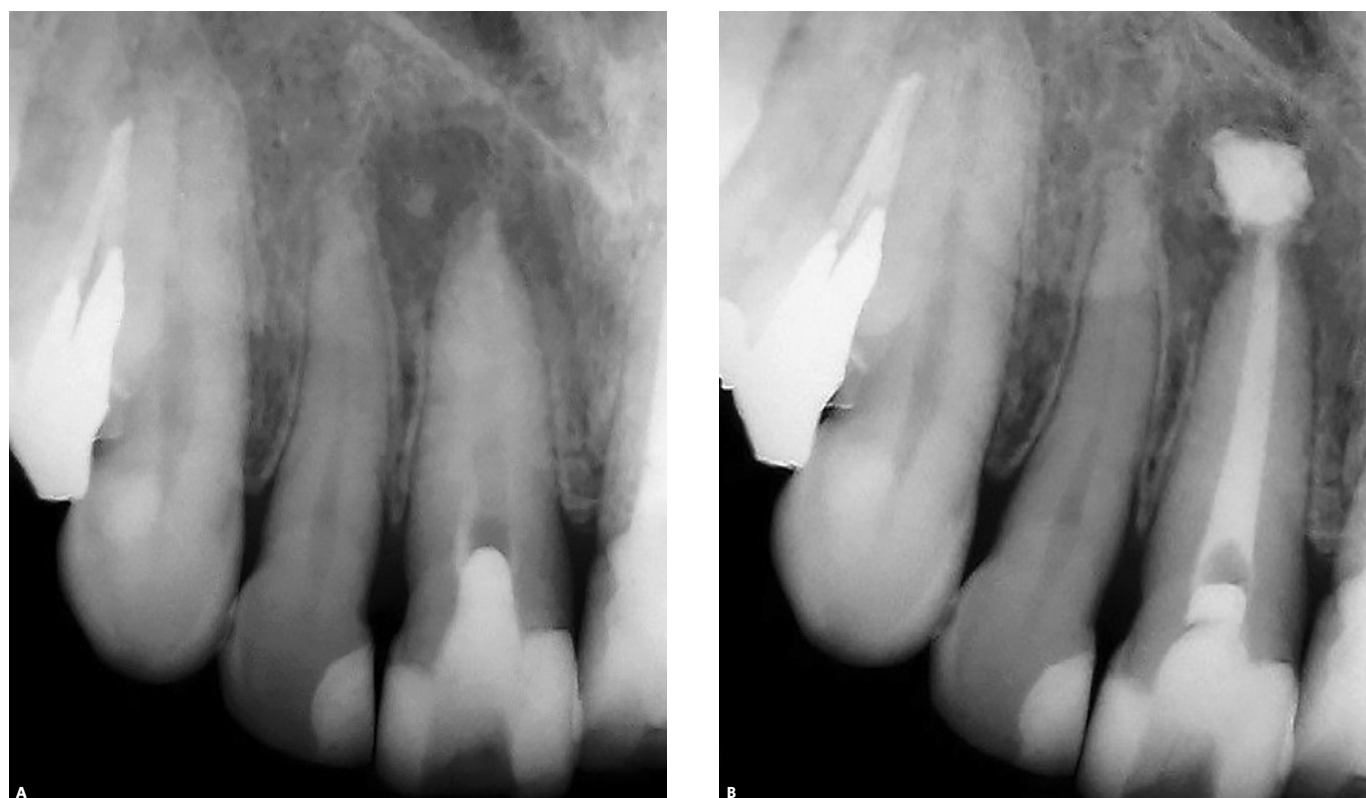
A) Radiograph shows increase of radiolucent area. B) Root canal filled with calcium hydroxide, 2% chlorhexidine gel and zinc oxide paste.
